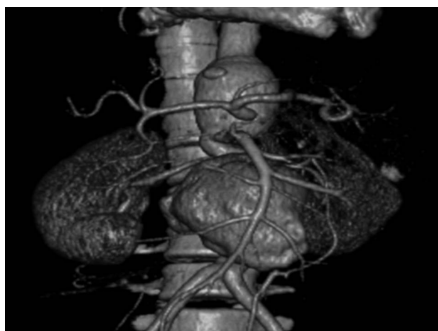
Aortic aneurysms. CTA of a 40-year-old female patient who presented with abdominal pain due to a leading aortic aneurysm.
